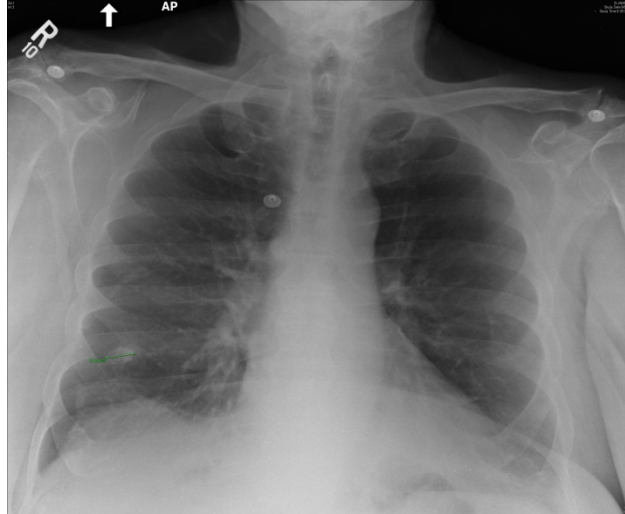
PA chest radiograph showing no causes for acute syncope.
